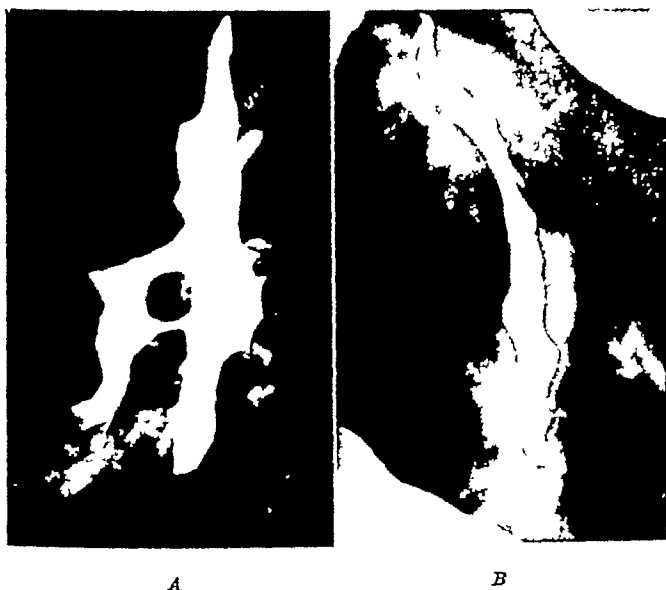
The intramural diverticulum was filled with barium postoperatively and a roentgenogram taken to show the extent and ramifications of the lesion. (A) Anteroposterior and (B) lateral views.
